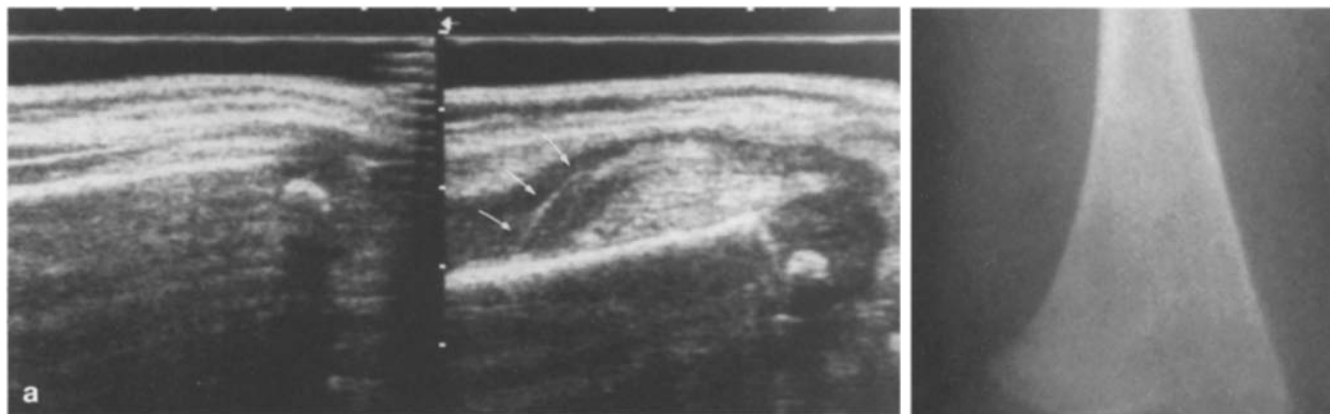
a, b Acute osteomyelitis in the distal femur of a 6-week-old boy. a Longitudinal sonograms on the day of admission (*right*, affected thigh; *left*, healthy side for comparison) demonstrating a massive predominantly hyperechogenic mass along the surface of the distal femur with elevation of the periosteum (*arrows*) and the adjacent soft tissues representing widespread subperiosteal abscess formation. b Plain radiograph (same day) showing localized lytic destruction of the distal femoral metaphysis and swelling of the adjacent soft-tissues
